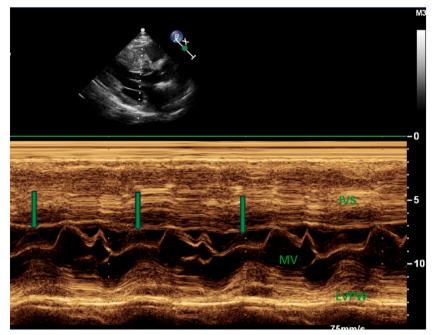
M-mode echocardiograms recorded in our patient with hypertrophic cardiomyopathy demonstrating disproportionate septal hypertrophy and SAM of the mitral valve (arrow).
